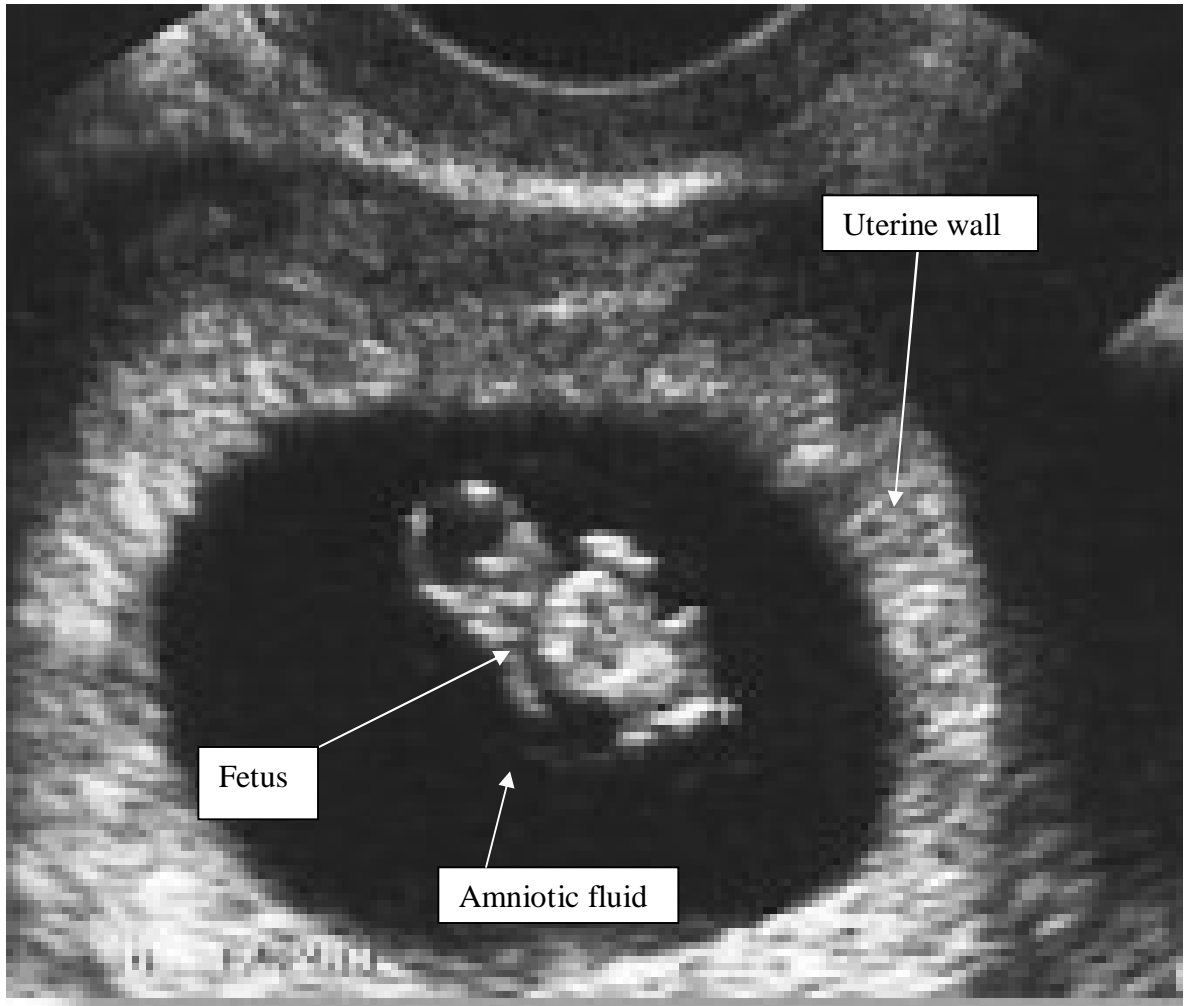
A picture of an ultrasound image of human fetus taken during an ultrasound examination session
